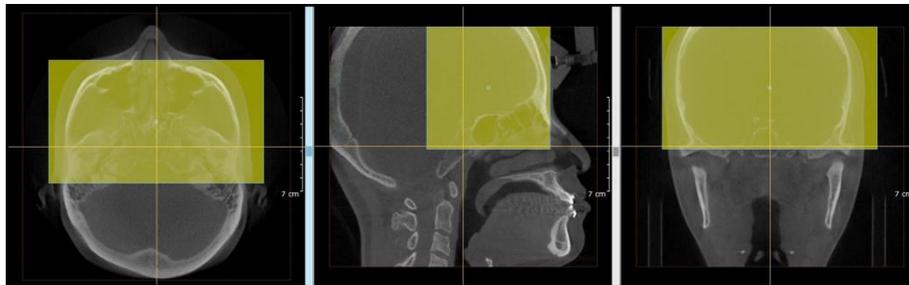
Superimposition of pre and postoperative 3-dimensional cone-beam computed tomography images using cranial base structures in OnDemand software. The yellow box indicates the superimposition area.
